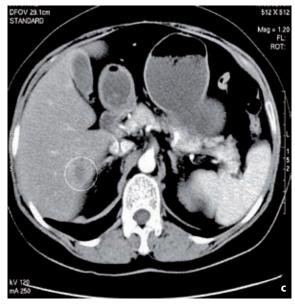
Metastatic liver cancer with rich blood supply: A – conventional ultrasound showed hypoecho in the right lobe of the liver and no evident blood flow signals (white circle); B – CEUS showed diffuse enhancement within 23 s (white circle); C – CECT displayed peripheral enhancement in arterial phase (white circle) and the hemangioma was considered
